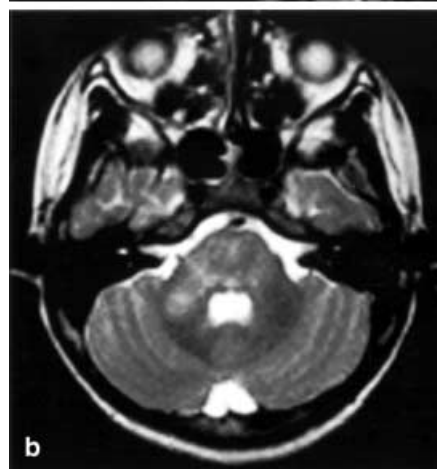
Patient 7. A 7-1/2-year-old boy who presented with dysarthria and left hemiplegia after an upper respiratory tract infection. FSE proton density axial MRI shows multiple oval-shaped hyperintense lesions in the deep and subcortical white matter of the frontal and parietal lobes. Other similar lesions were noted in the thalamus and in the posterior limb of the right internal capsule
